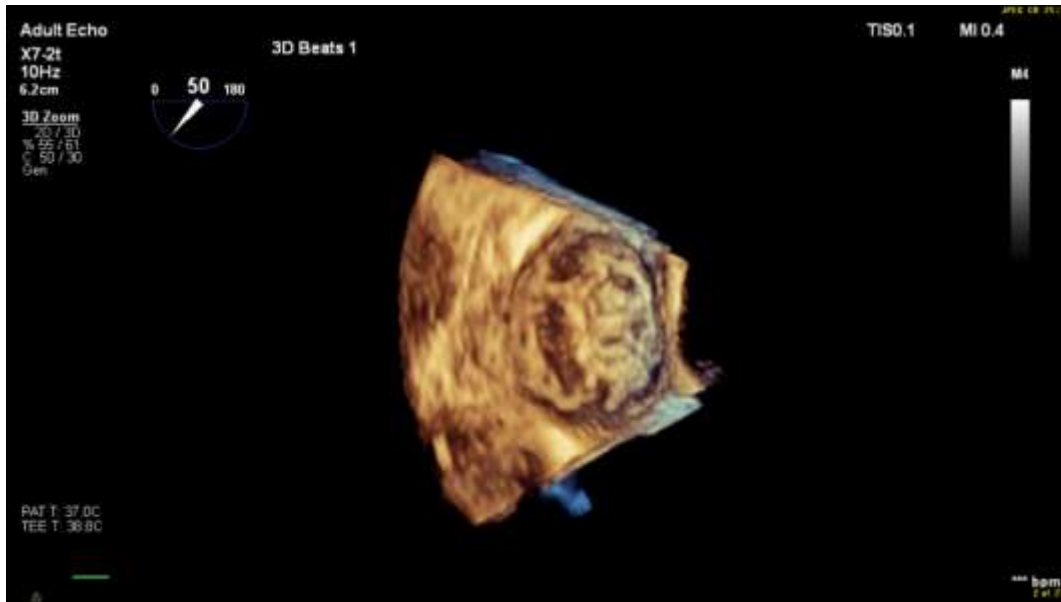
3D Echocardiogram showing appendage occluder device with appendage visible.
